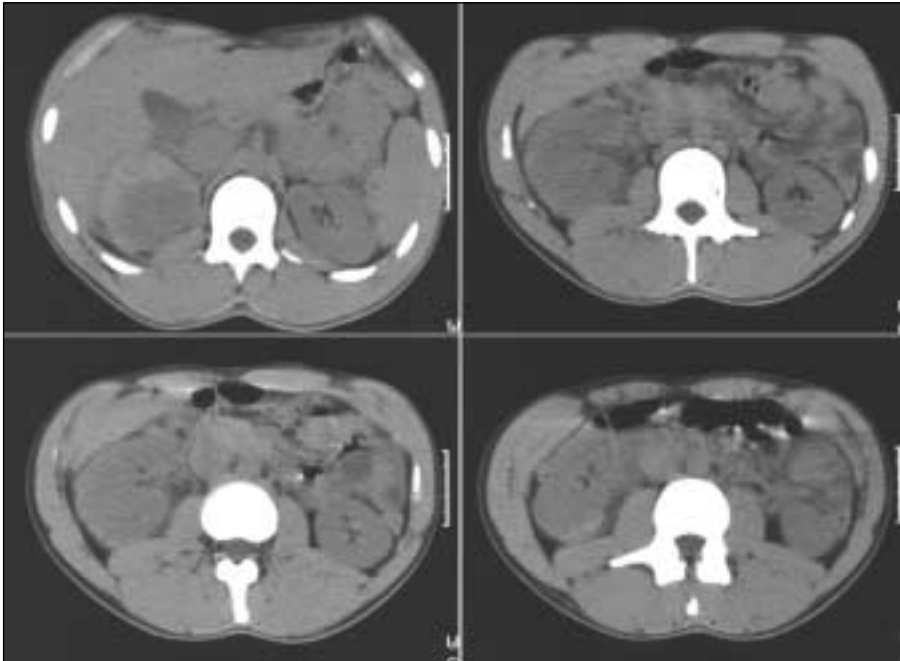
Pre-intravenous contrast enhanced CT scans.
